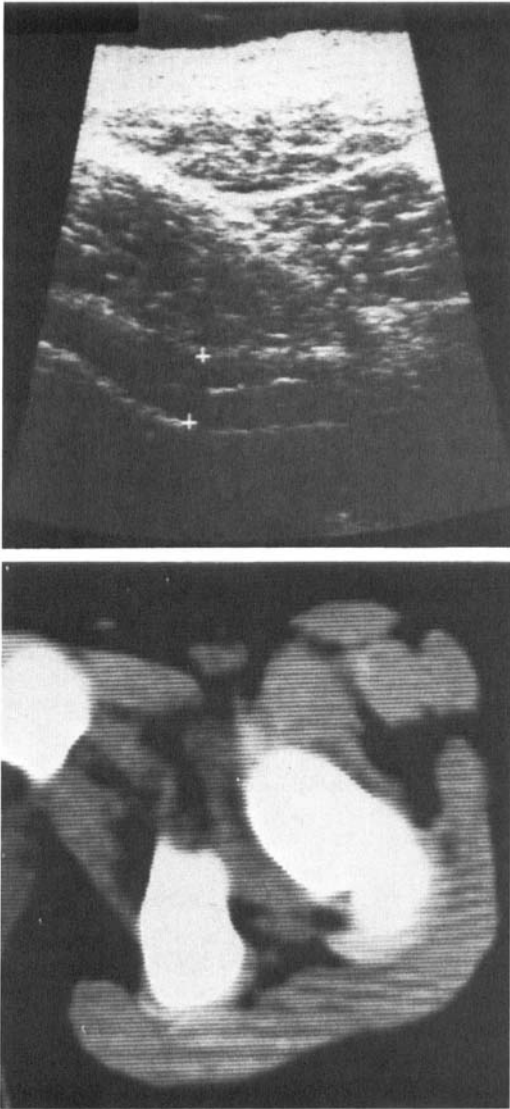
Ultrasonography (top) and CT (bottom) of the left hip immediately after aspiration of 5.5 ml of joint fluid. The ventral distension of the capsule has been reduced from 10 to 2 mm.
